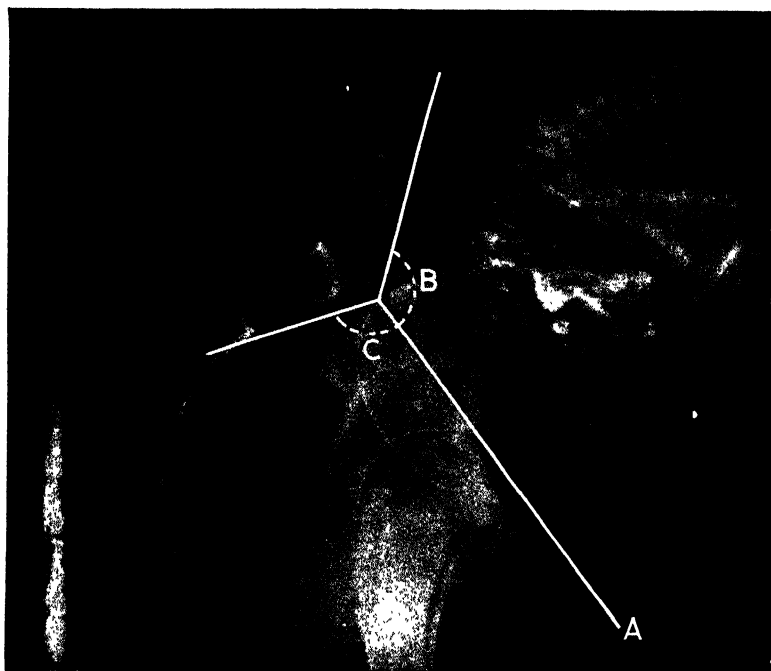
A lateral X-ray of the pelvis, the foetus is in an occipito-posterior position (Chassar Moir).
